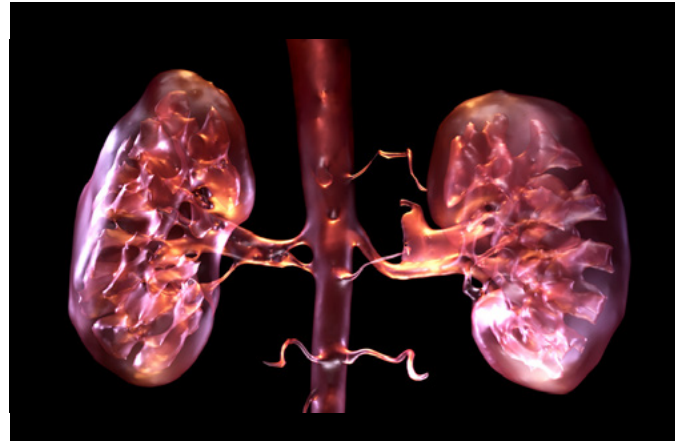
/ 'Medulla'—visualisation 2. Final stage image: a 3D CGI rendering of human kidneys from clinical renal angiogram MRI data, represented as glass-like structure rather than soft organic tissue. Copyright by John McGhee.
